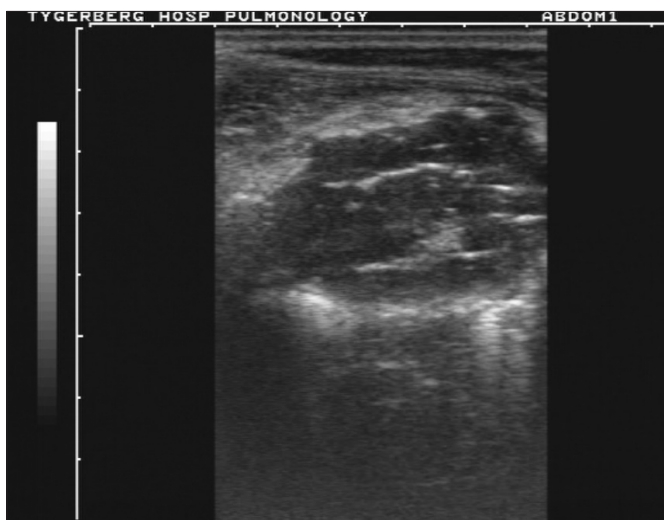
Ultrasound image (high frequency) of the rib lesion seen in Fig. 4.
